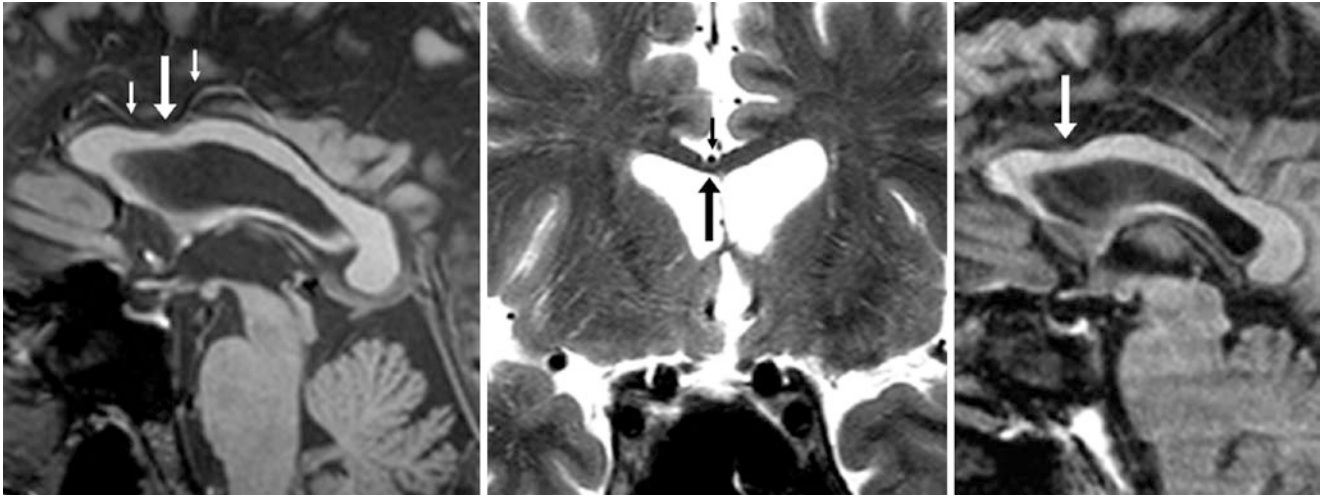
A 62 year old who underwent a 3T MRI (negative) demonstrating normal compression of the posterior genu–anterior body of the corpus callosum (arrows) on a sagittal midline T1WI (left). A coronal
